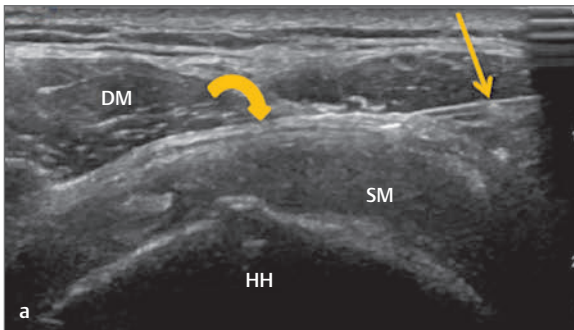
(a–d) Ultrasound image of the anterolateral aspect of the shoulder. This transverse image demonstrates the supraspinatus muscle (SM) overlying the humeral head (HH) and deep to the deltoid muscle (DM). The subacromial bursa (*curved arrow*) may be seen as an echogenic line. A needle may be seen entering the bursa from the right side of the image (*straight arrow*). In these sequential images the bursa may be seen to distend with fluid as the injection is delivered.
